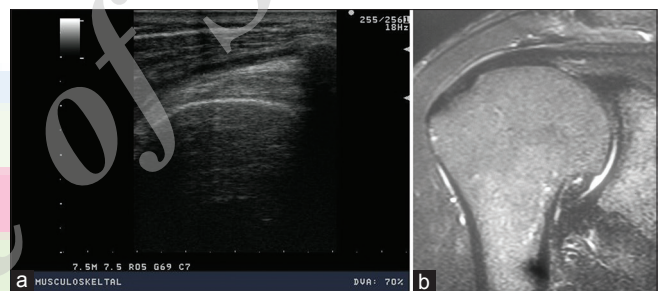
(a) Short-axis ultrasound image showing normal supraspinatus tendon. (b) Coronal T2-weighted image showing normal supraspinatus tendon
